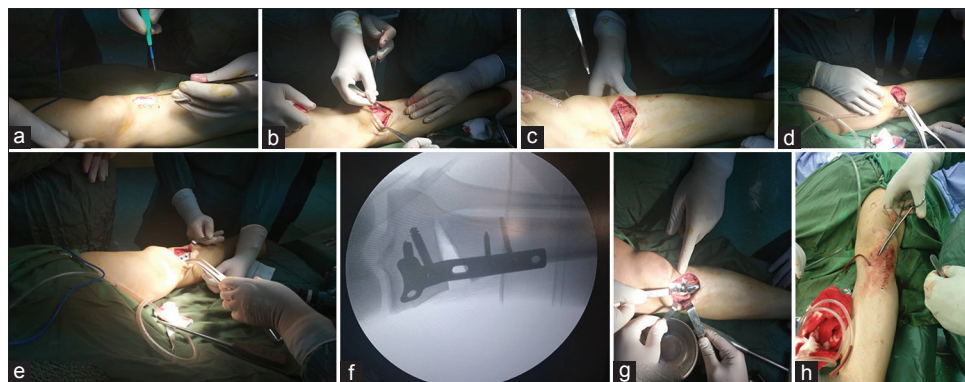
The process of high tibial osteotomy; (a) longitudinal incision of proximal of tibia, (b) the exposure of site of osteotomy, (c) the process of osteotomy at the proximal of tibia, (d) opening of wedge using lamina spreader, (e) plate embedding at the tibia proximal, (f) radiography during the surgery using c-arm device and the varus deformity correction found in the radiography, (g) the filling of osteotomy site by allograft, and (h) the subcutaneous and cutaneous suturing, and hemobag embedding
